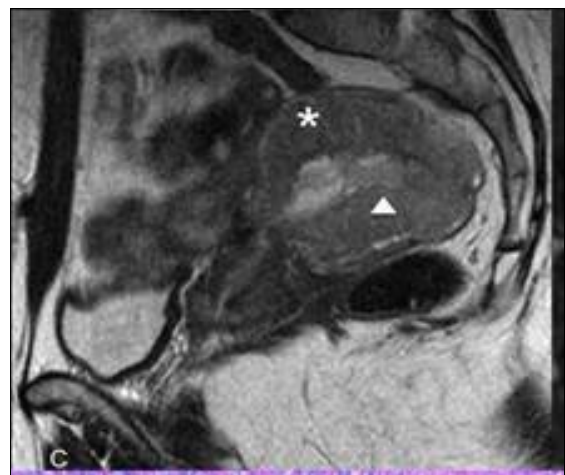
MRI imaging of PSTT
